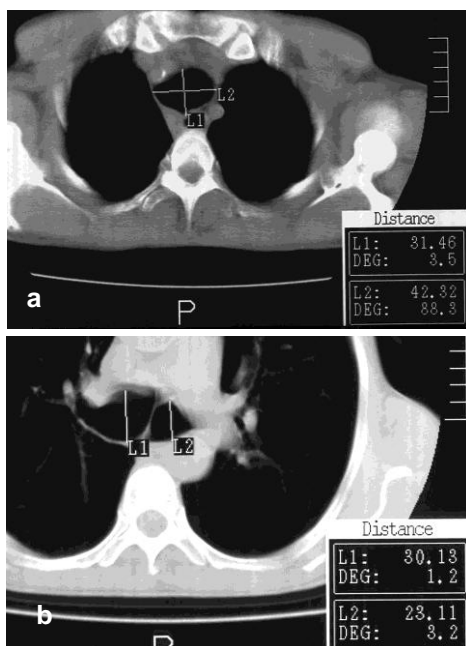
One year later, control axial chest CT of same case shows (a) increased diameters of trachea and (b) main bronchi.
